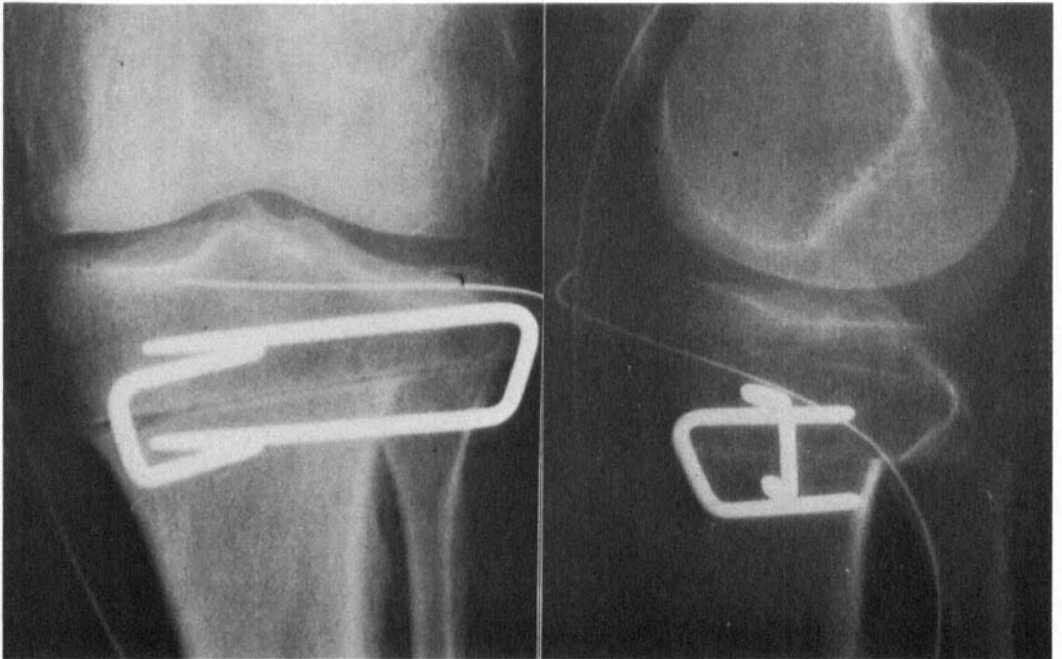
Postoperative x-rays.
